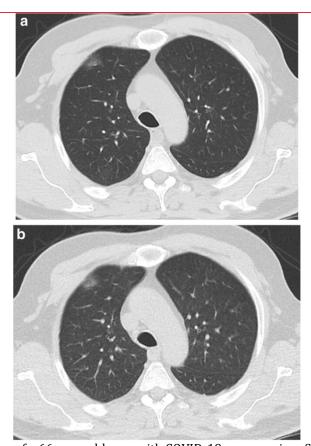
Example chest CT scan of a 66-year-old man with COVID-19 pneumonia. a Standard-dose image; a peripheral patch of ground glass opacity is seen in the anterior segment of the right upper lobe. b Low-dose image at the same level; the lesion is clearly visible. The lesion was scored 2 (definitely present) by all the readers, both on standard- and low-dose CT scans.
